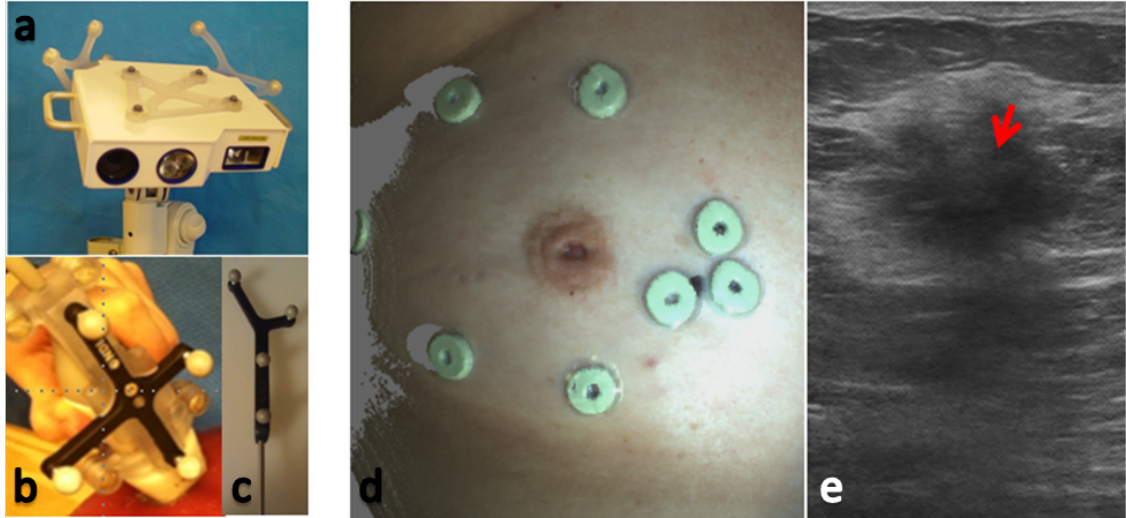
(a) Laser range scanner with rigid bodies for tracking. (b) Ultrasound transducer with rigid body for tracking. (c) Tracked pen probe. (d) Textured point cloud produced by tracked laser range scanner with known 3D coordinates. The green rings are MR visible adhesive fiducial markers. (e) Example of a 2D ultrasound slice of a breast tumor (dark shadow shown by red arrow).
